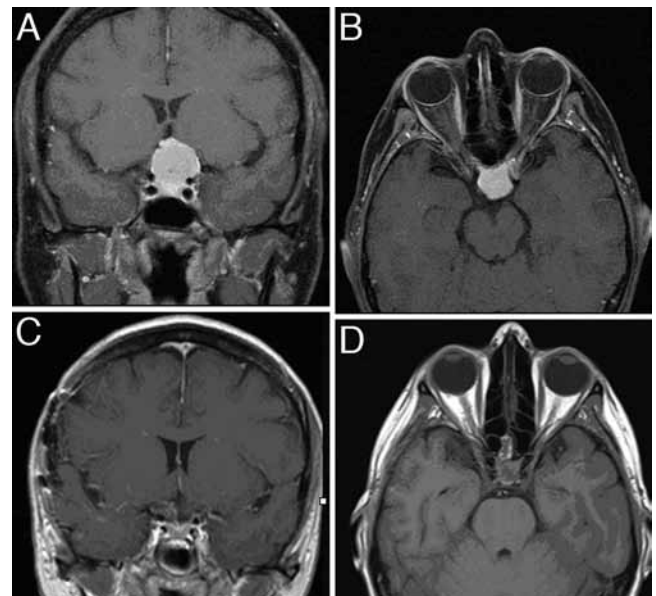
Case 17. Preoperative coronal T1-weighted MR image with contrast enhancement (A) and axial contrast-enhanced, fat-suppressed T1-weighted MR image (B) demonstrating an avidly homogeneously enhancing TSM compressing the optic chiasm, with significant compression of the left optic nerve. Postoperative coronal (C) and axial (D) contrast-enhanced, fat-suppressed T1-weighted MR images showing that GTR was achieved via a TCR after the mass was found to be extremely hard and not amenable resection via the ETSA.
